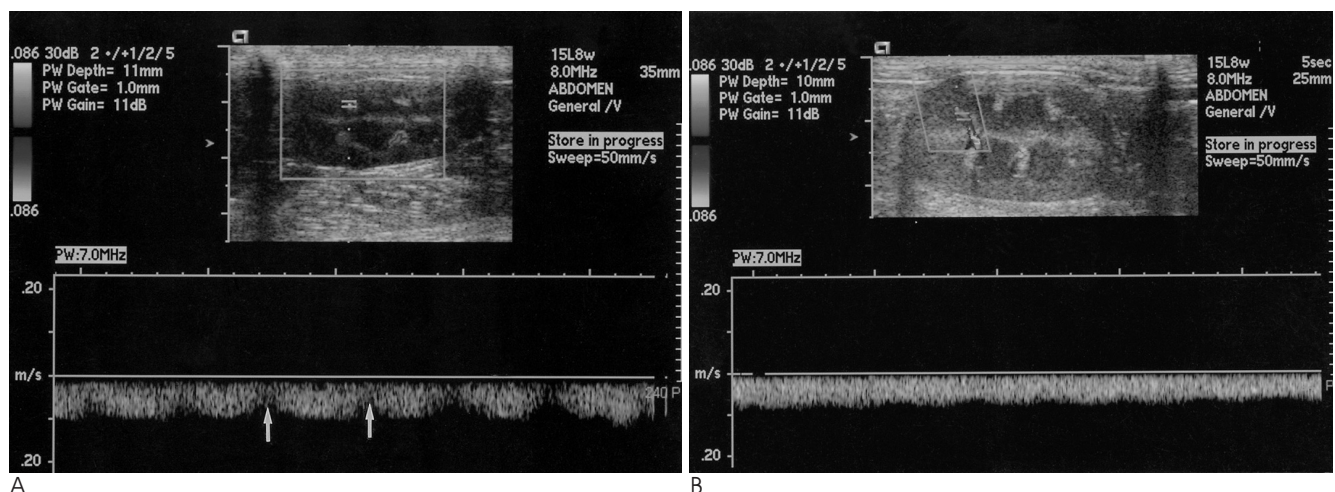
A. Duplex Doppler sonogram of left kidney before ureteral ligation. Doppler sonogram on interlobar vein shows oscillating, wavy Doppler form of the renal vein with periodic reduction of the venous flow (arrows). The impedance index of interlobar vein was 0.4.
